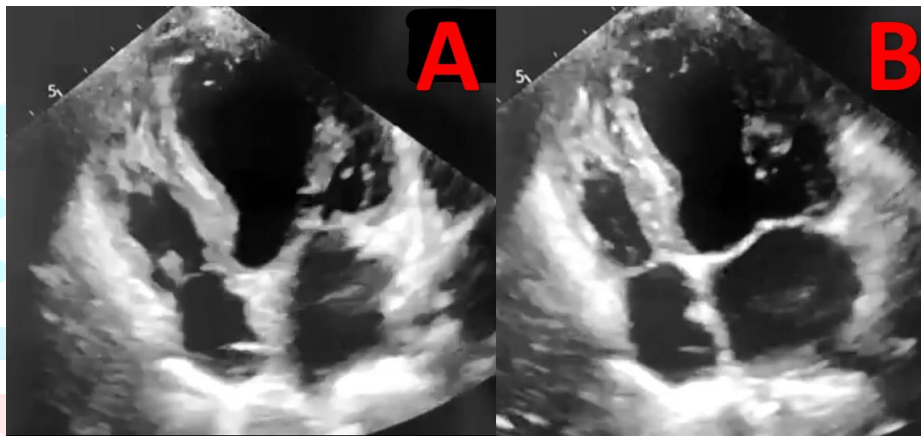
Trans-thoracic echocardiography (TTE) conducted using apical 4 chamber imaging, two days after the implantation of a pacemaker, reveals a dilated left ventricle in the end-diastolic image (A). Additionally, systolic apical ballooning with dyskinesia and mid ventricular hypokinesia are seen (B). These findings occur prior to the installation of pericardial effusion.
